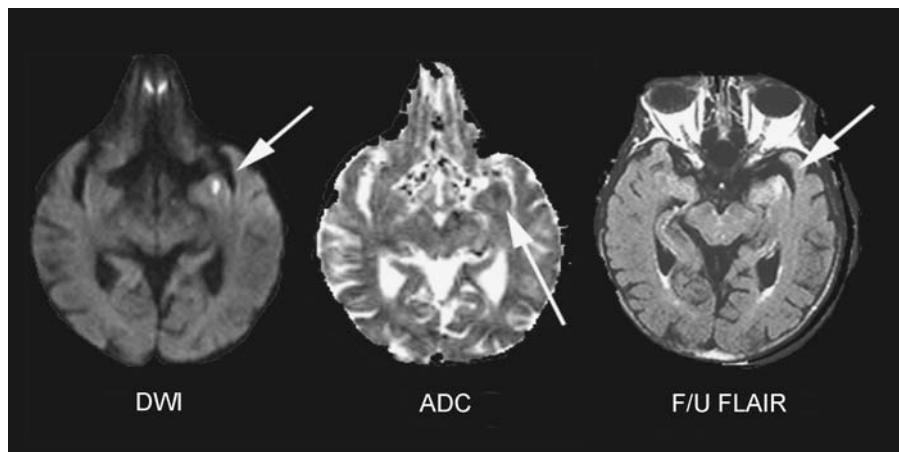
Transient global amnesia. Seventy-seven-year-old female with acute transient global amnesia that resolved within 24 hours. There is a punctate DWI hyperintense and ADC hypointense lesion in the left medial temporal lobe (*arrows*). The lesion persists on follow-up FLAIR images. Abbreviations: DWI, diffusion-weighted images; ADC, apparent diffusion coefficient; FLAIR, fluid-attenuated inversion recovery.
